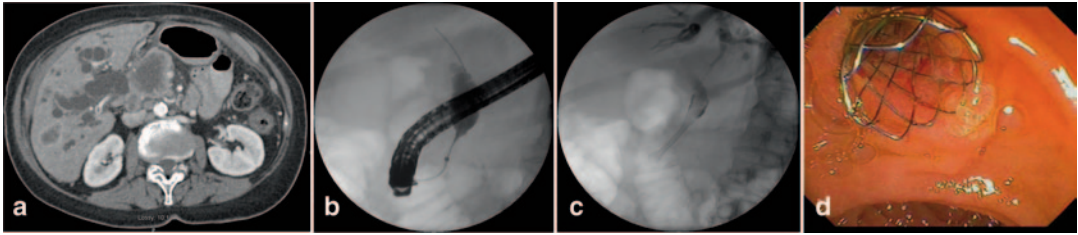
a Pancreatic cancer with diffuse intrahepatic biliary dilation on abdominal CT, b confirmed by cholangiogram showing distal biliary stricture, c, d treated by metal biliary stent placement. *CT* computed tomography
